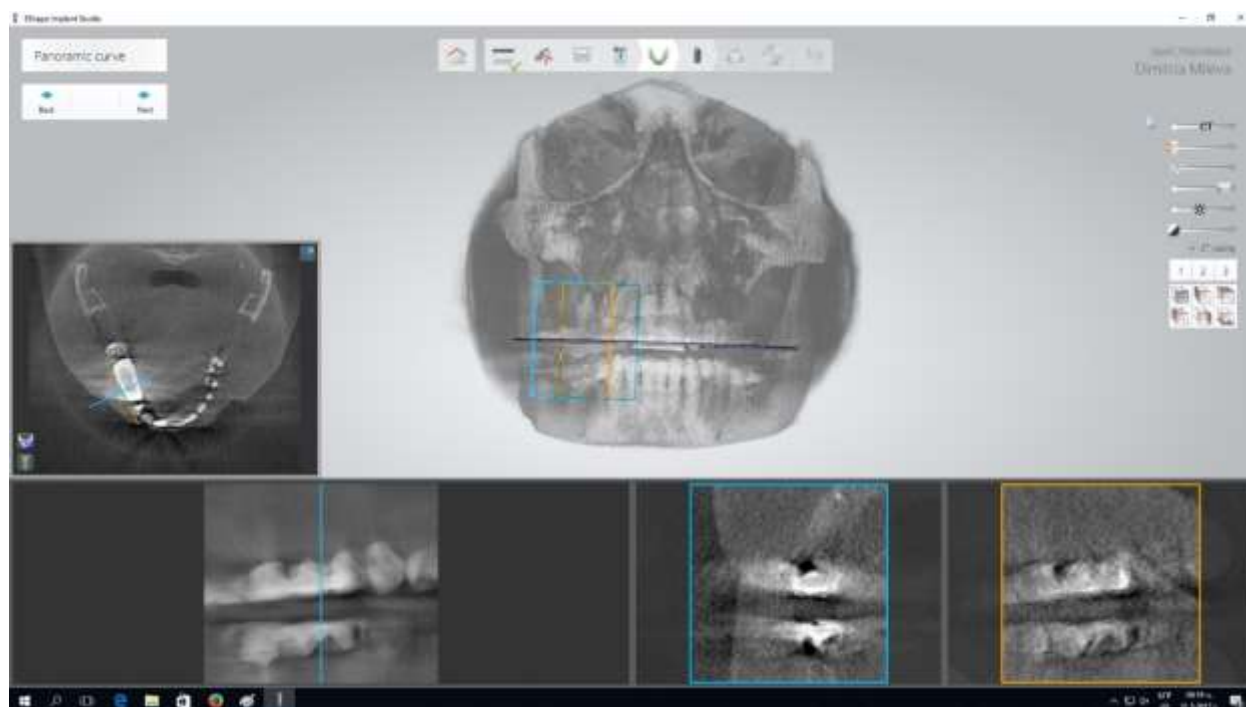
Outlines of the prognostic teeth crowns of the final restoration visible on the CBCT scan.
